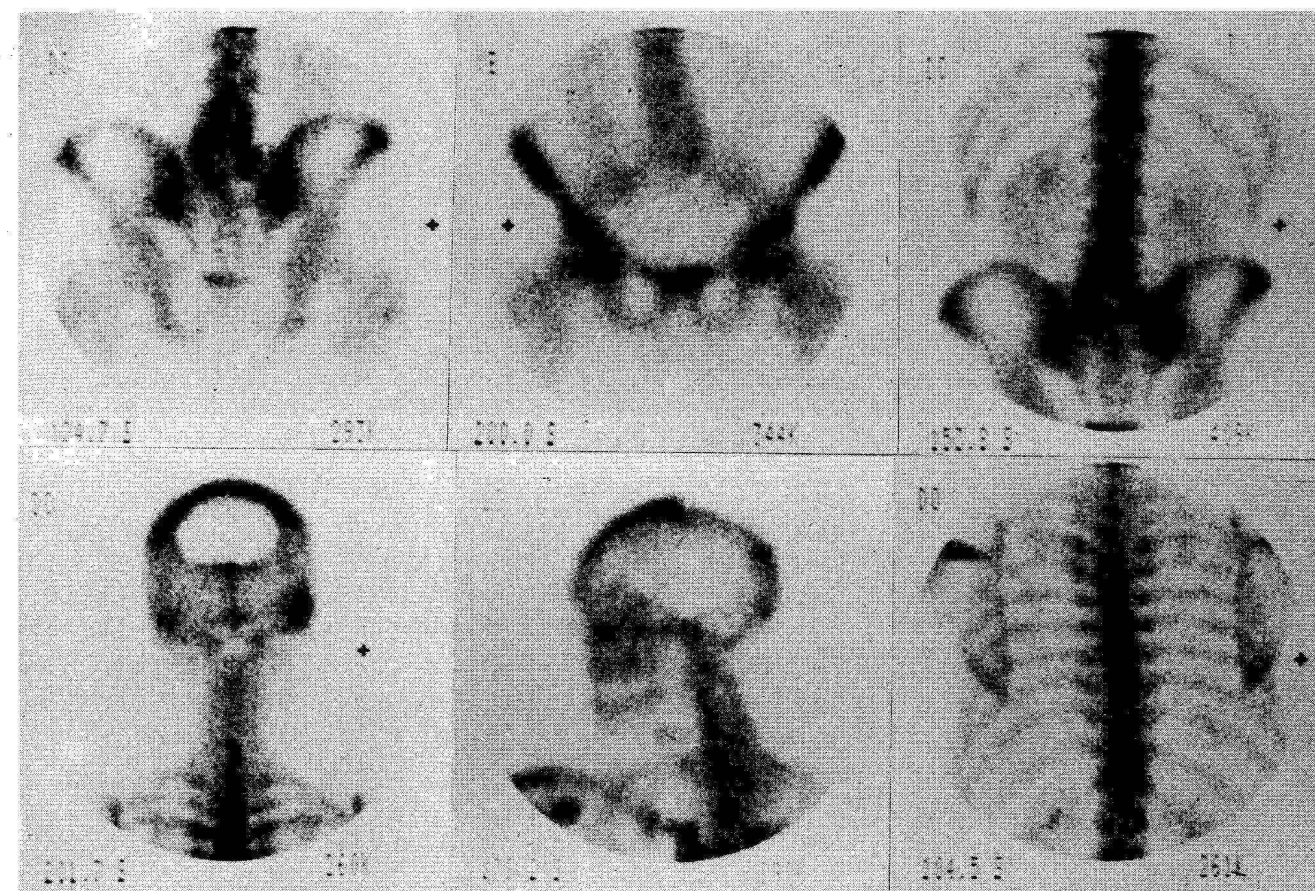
Bone scintigram. Spotty higher concentration in the vertebral bodies of the lower lumbar spine and in both iliosacral joints. Occipital a great osteoclastic defect, after implantation of a calvarian plastic.
